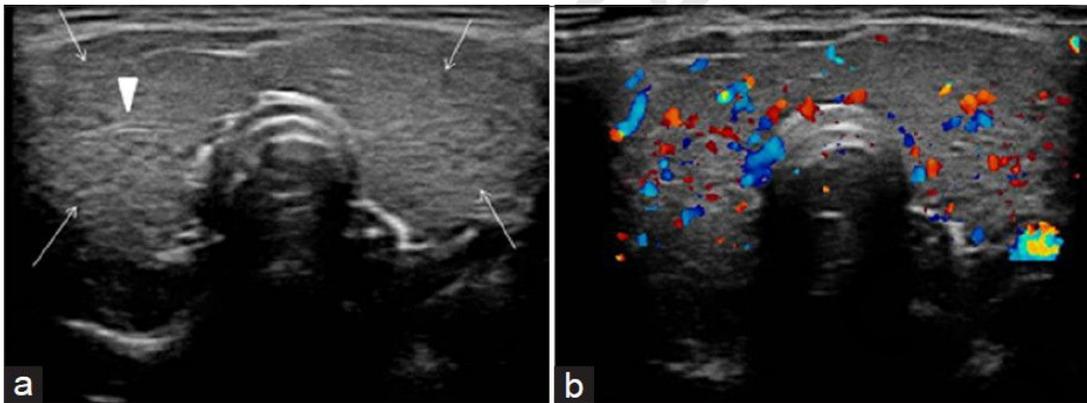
Diffuse Hashimoto's thyroiditis in a 35-year-old female patient, who presented with features of hypothyroidism and had anti-thyroid antibodies positive for the disease. Transverse gray-scale ultrasound neck (a) demonstrates diffuse enlargement of thyroid gland with heterogeneous echo texture. Multiple tiny and discrete hypo echoic nodules (micro nodules, arrows) and few linear echogenic septae (arrowhead) are also noted. Color Doppler sonogram (b) demonstrates mildly increased parenchymal vascularity.
